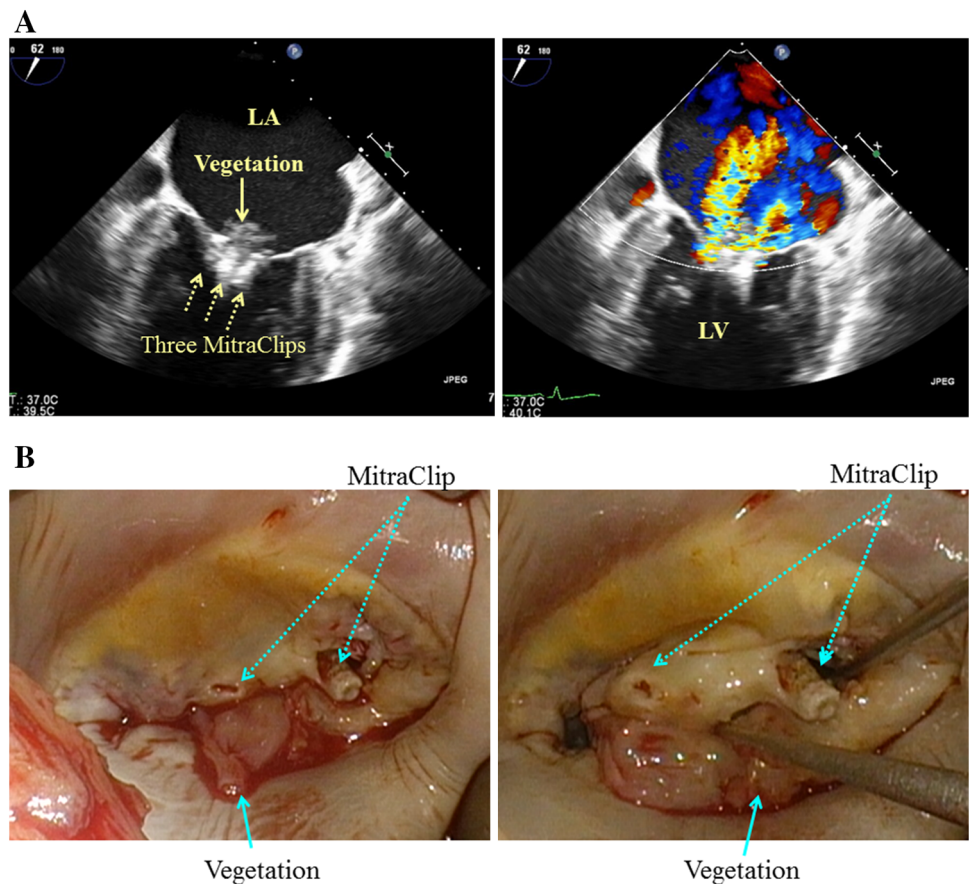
a Preoperative transesophageal echocardiographic image of the case 2. An 1–1.5 cm vegetation is seen on the mitral valve leaflet where the MitraClips were implanted (left). The color Doppler image shows the recurrent severe mitral regurgitation. b Intraoperative view of the mitral valve of the case 2. The vegetation was located at the P2 segment of the posterior mitral leaflet. Degenerative changes were observed on the both leaflets around the MitraClips
